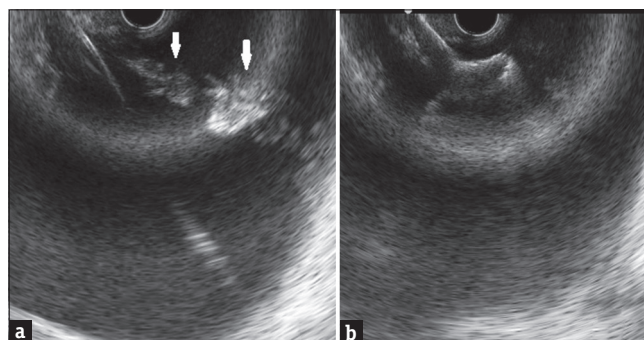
(a) Endoscopic ultrasound: Spurt of echogenic contents being observed from the dilated site. (b) Endoscopic ultrasound: bi-flanged fully covered self-expanding metallic stent being deployed leading to cessation of bleeding
